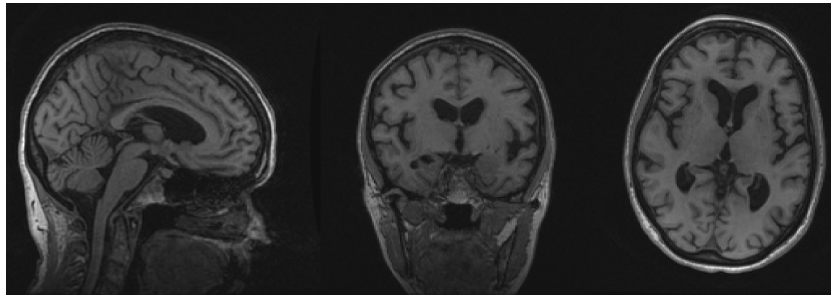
MRI after reorientation.
